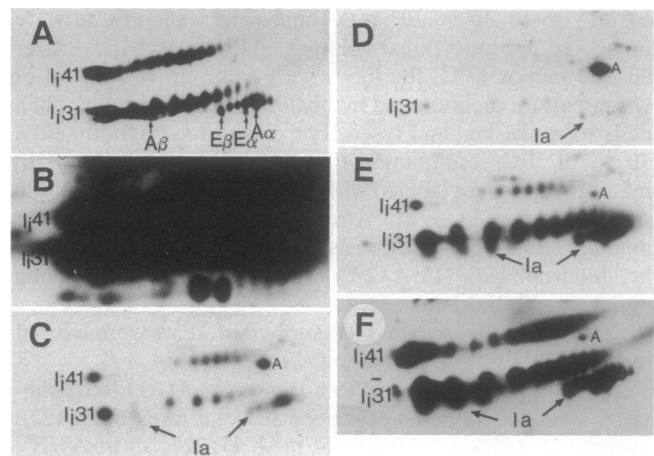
Biosynthesis of class II and invariant chain polypeptides in LCs and DCs. LCd0 (A, B, and F), LCd1 (C), LCd3 (D), and spleen DCs (E) were metabolically labeled for 1 hr with [35 S]methionine and lysates were immunoprecipitated with anti-class II (A–E) and anti- I_i (F) mAbs. To demonstrate the decreasing intensities of the two-dimensional pattern, the gels in B–E were exposed to x-ray films for 25 days. In addition, the two-dimensional gels in A and F were exposed for 1 day. Class II chains are denoted with $A\beta$, $E\beta$, $E\alpha$, $A\alpha$ (A) or with Ia (C–F). I_i41 and I_i31 are coprecipitated invariant chains. Note the marked decrease in biosynthesis upon culture of LCs (B–D). Assignment of the spots was done by using defined class II/ I_i transfectants (22). A, actin.
